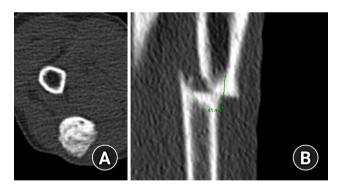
Axial computed tomography image at the level of sclerotic bone lesion without medullary canal (A). The length of both sclerotic margin ends was over 8 mm (B).
